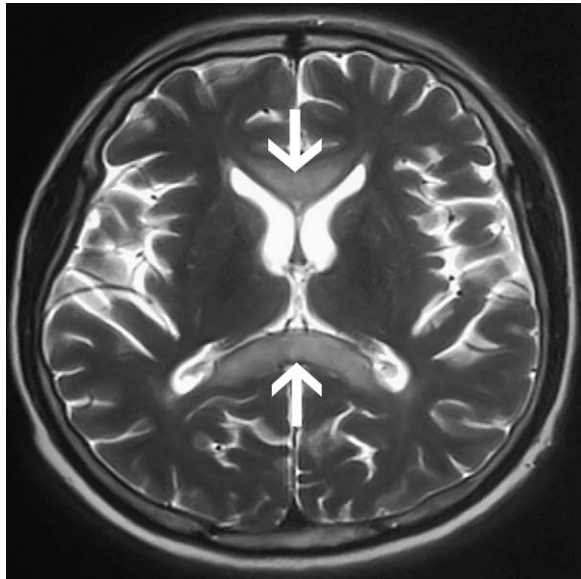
MRI T2-weighted.
